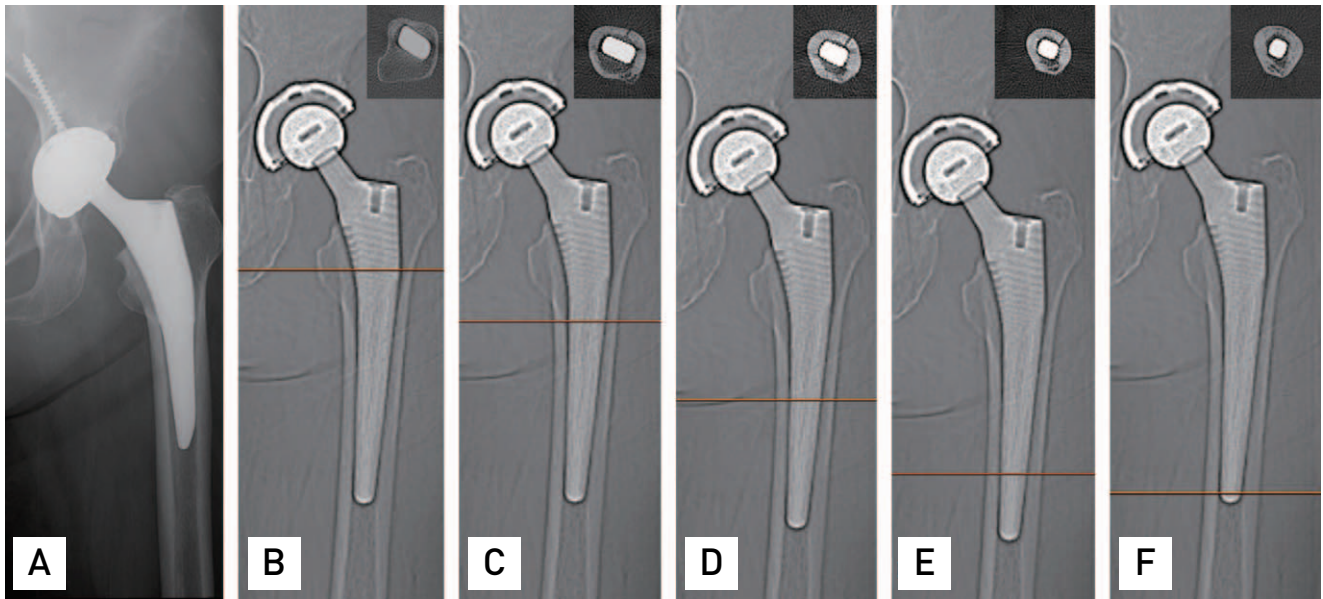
A 69-year-old female who underwent primary total hip arthroplasty using a Corail® stem. (A) Immediate postoperative radiograph. (B-F) Immediate postoperative computed tomography (CT) images. A fracture line starting from the region below the lesser trochanter located at the anterior cortex and extending to the distal one-third of the femoral stem was observed on axial CT images.
